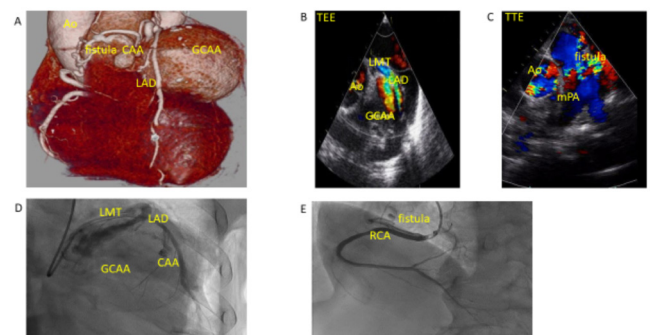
A, Computed tomography coronary angiography showed a large 71-mm aneurysm adjacent to the LAD and a concomitant smaller aneurysm. B, TEE showed a 66 × 52-mm aneurysm adjacent to the left ventricle with no direct communications to the cardiac cavities. Blood flow from the proximal portion of the LAD into the aneurysm was delineated during diastole. C, TEE showed multiple fistulae to the main PA. D, CAG showed blood flow from the proximal portion of the LAD into the aneurysm. E, CAG showed multiple fistulae entering from the RCA to the main PA.
